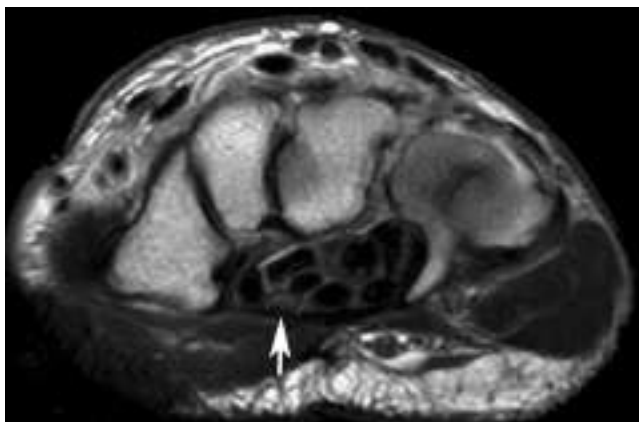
Normal nerve. Axial T2-weighted fast spin-echo MR image obtained through the wrist shows the intermediate-signal-intensity median nerve (arrow) in the carpal tunnel. Contrast with the low signal of the carpal tunnel tendons.
